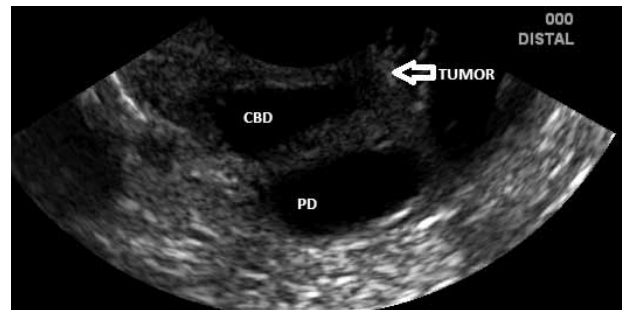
Endoscopic ultrasound showing a small ampullary tumor (arrow) with dilated common bile duct and pancreatic duct
